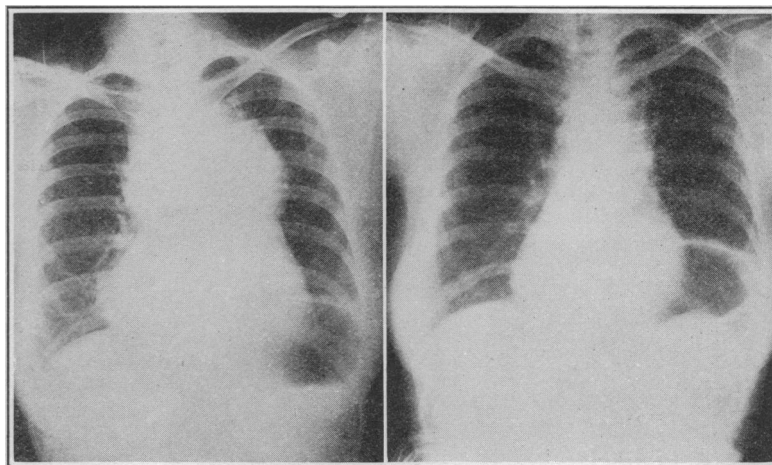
Roentgenogram made September 2, 1929, showing a large bilateral mediastinal tumor.
